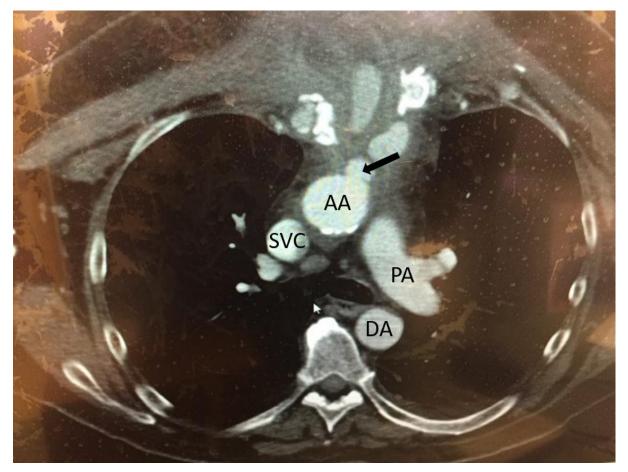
CT Angiogram demonstrating aortic pseudoaneurysm. AA – Ascending Aorta, PA – Pulmonary Artery, SVC – Superior Vena Cava, DA – Descending Aorta. Arrow demonstrates site of aortic defect.
